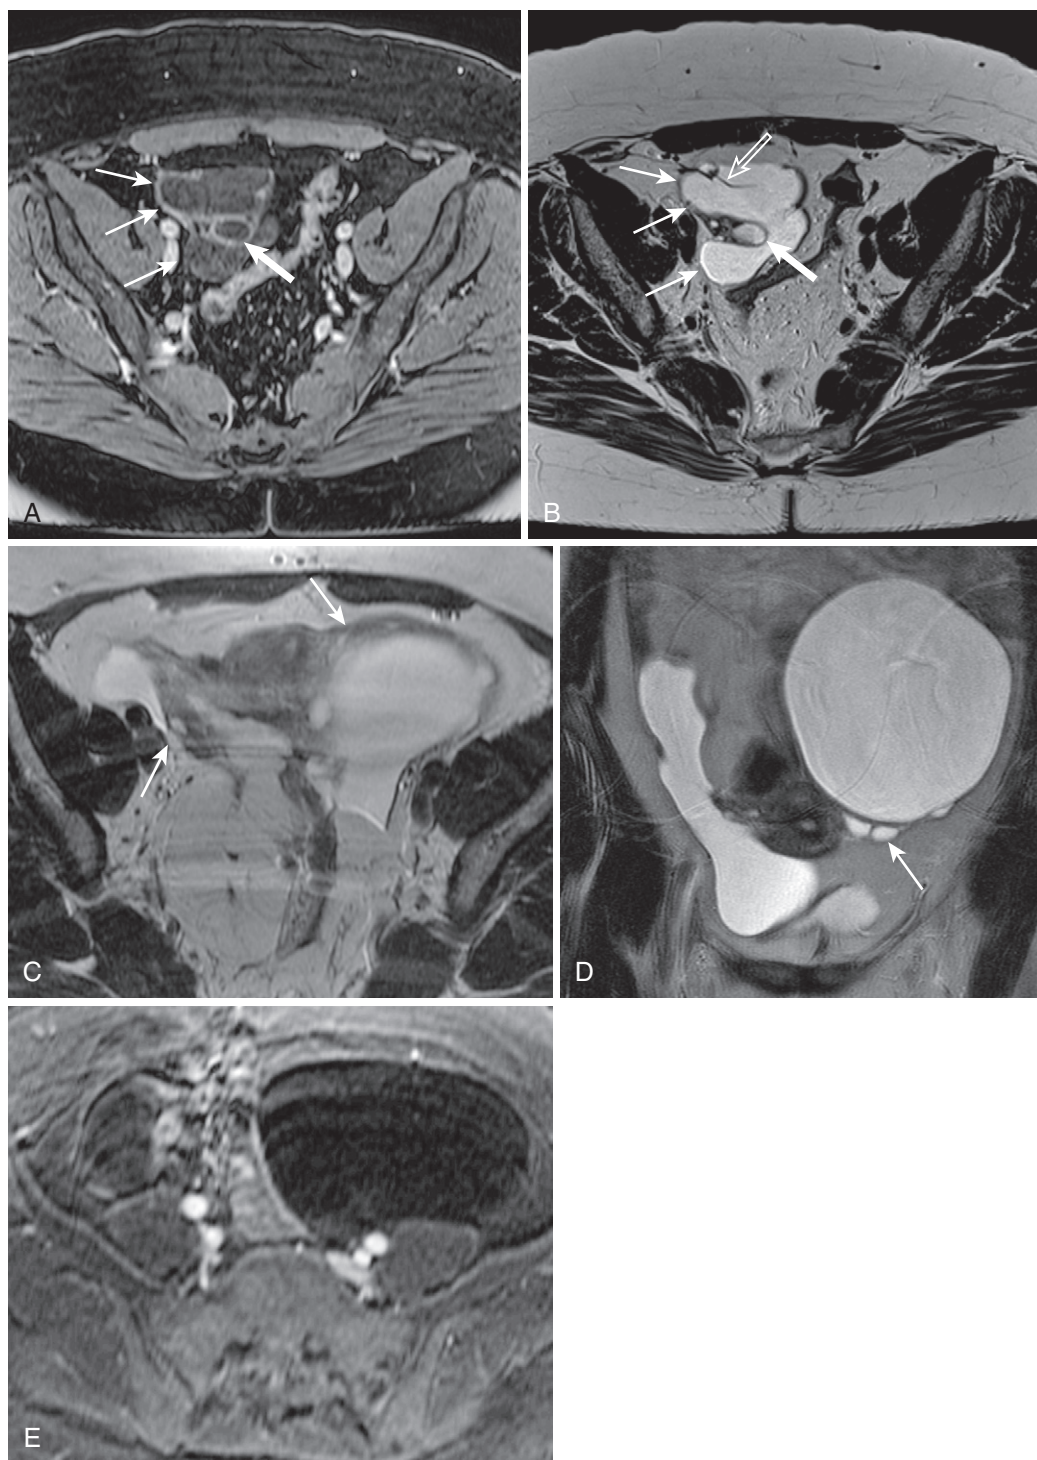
Peritoneal inclusion cyst. A and B, The lateral margin (*thin arrows* in A) of a fluid collection encircling the right ovary (*thick arrow* in A and B) is bounded by the pelvic sidewall. Minimal wall thickening (*thin arrows* in B) and internal septation (*open arrow* in B) are observed—seen to better advantage on the enhanced image (A) compared with the T2-weighted image (B)—and the features are characteristic of a peritoneal inclusion cyst. Axial (C) and coronal (D) T2-weighted and axial enhanced T1-weighted (E) images in a different patient reveal bilateral cystic lesions abutting the ovaries (*arrows* in C and D) and at least partially spatially defined by anatomic borders—namely, the pelvic sidewalls. The left-sided lesion appears more masslike and an appropriate clinical history (i.e., surgery), stability, and an absence of neoplastic features should be confirmed.
